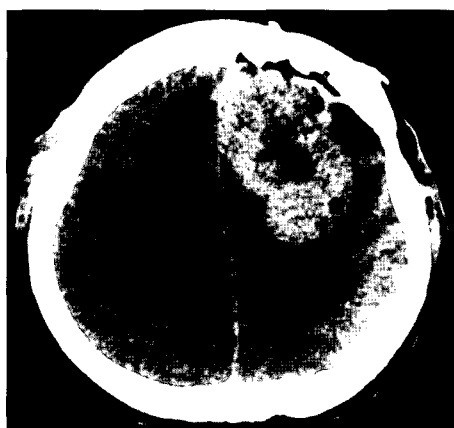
CT after the second operation and before the radiation therapy in Case 1.
